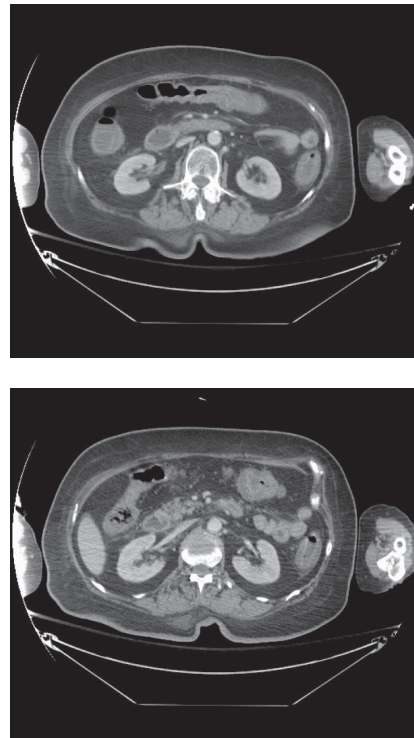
Computed tomography of abdomen/pelvis with pancolitis noted; with colonic wall thickening of the distal transverse, splenic flexure, descending colon, and sigmoid colon.
